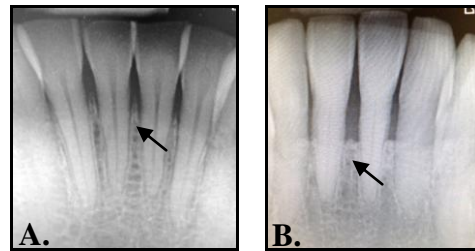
Radiographs featuring (A) healthy and (B) diseased periodontal tissues. Arrows indicate margins of the alveolar bone.
